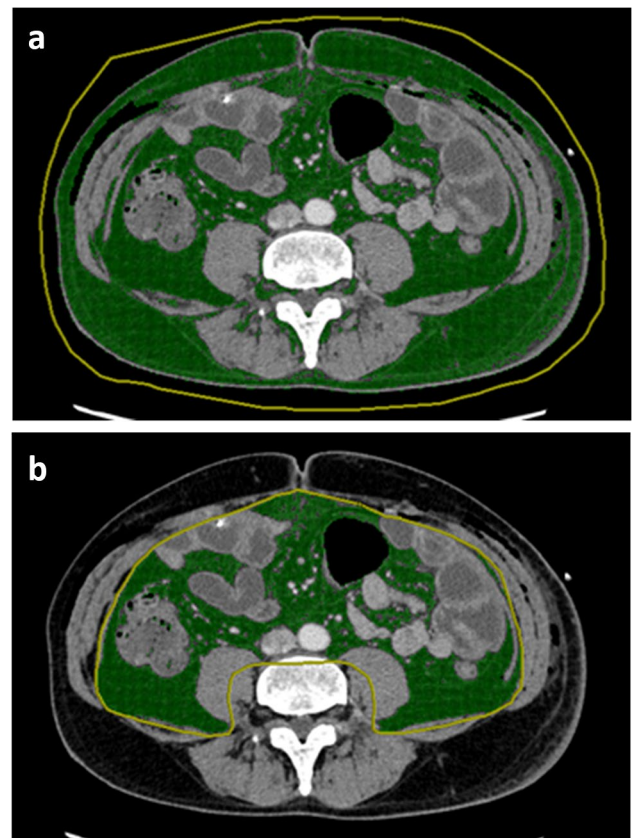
Measurement of the green area surrounded by the yellow line in CT. a Measurement of the total fat area (TFA). b Measurement of the visceral fat area (VFA)
